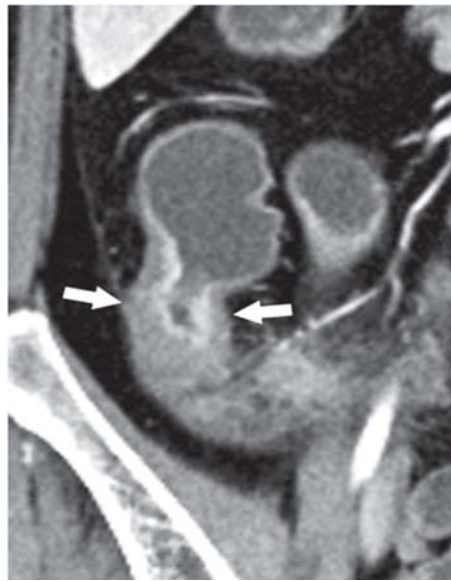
Coronal enteric phase CT enterographic image shows mural hyperenhancement, mural stratification, and wall thickening in terminal ileum (arrows)
